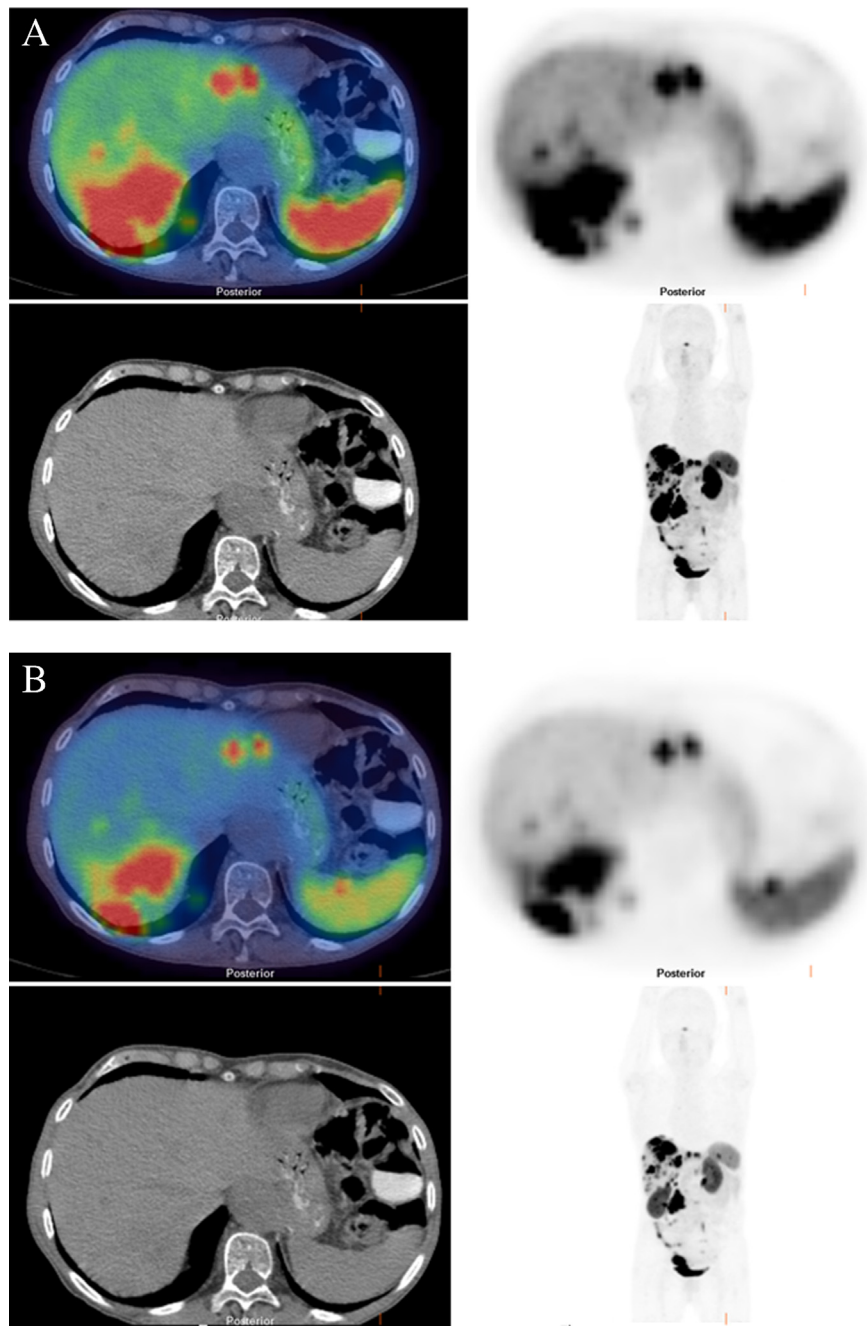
A 66-year-old female patient with metastatic midgut NET was referred for ^{68}Ga -DOTATATE PET/CT for staging. Imaging demonstrates avid uptake in a mesenteric mass and within multiple liver metastases. On the first more intensely windowed PET image (A), no obvious abnormal uptake is seen in the spleen. However, when the window is altered to less intense (B), it can clearly be seen that there is focal uptake in the spleen indicative of a splenic metastasis. Learning point: Altering the windowing is essential in areas of high physiological background or adjacent to a tumor with high-grade uptake.
